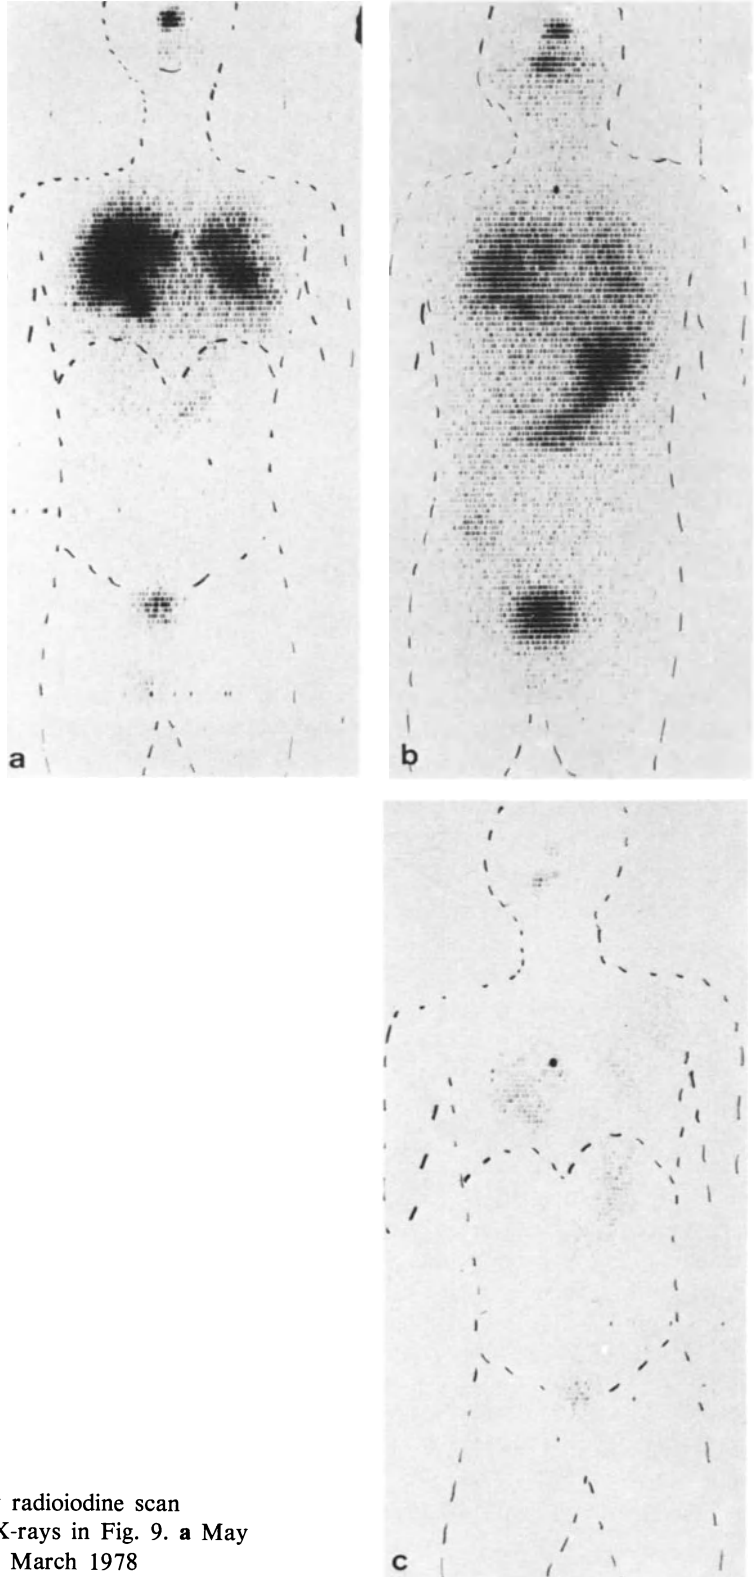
Whole-body radioiodine scan corresponding to chest X-rays in Fig. 9. a May 1977; b August 1977; c March 1978
